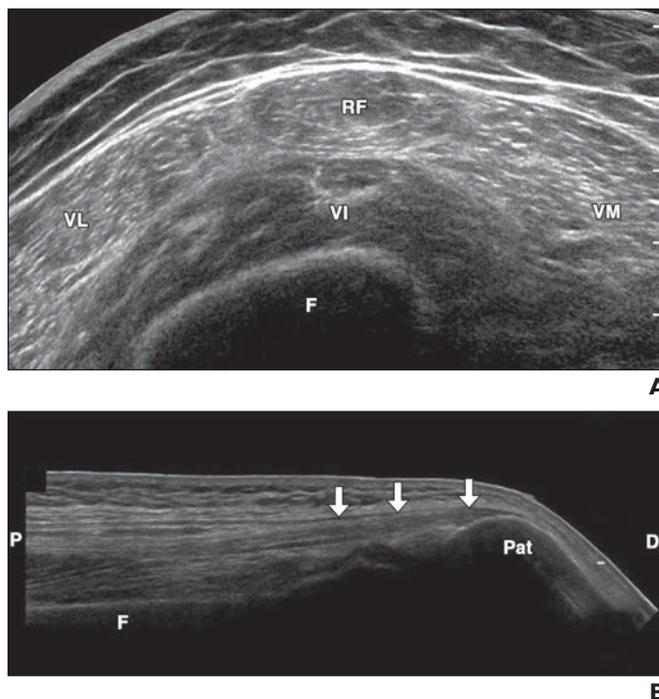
31-year-old man with normal sonogram of rectus femoris.
